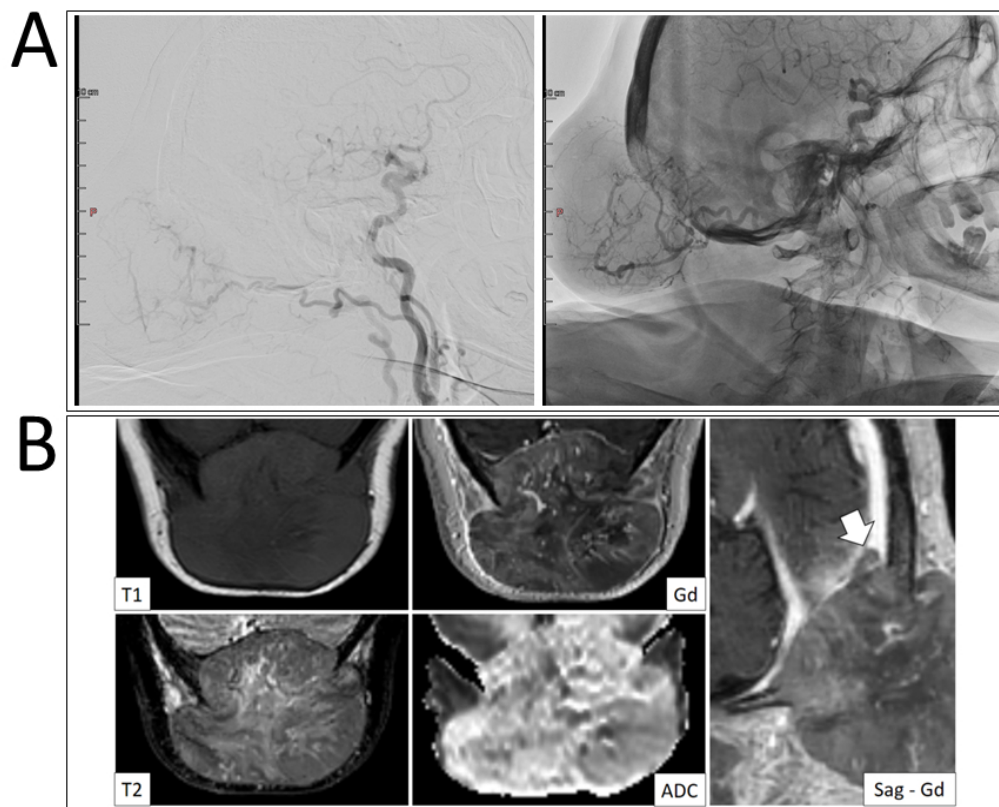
A) Angiographic image showing the rich arterial vascularization of the occipital neoplasm and the hypertrophy of the occipital arteries. Technical notes: using a right transfemoral catheterization with a 5-F introducer, a selective study of the internal carotids, external carotids, and vertebral arteries was performed. The study demonstrated significant contributions to the lesion from the occipital arteries on both sides. Siemens Artis Zee angiography system. B) MR imaging (axial T1 Spin Echo (T1-SE) before and after injection of gadolinium (Gd); axial T2 Fast Spin Echo (T2-FSE); Apparent Diffusion Coefficient (ADC)). Occipital mass, heterogeneously hypointense in T1 and hyperintense in T2, characterized by moderate heterogeneous contrast enhancement. No significant diffuse restriction was detected by diffusion-weighted imaging (ADC map). On the sagittal plane, post-gadolinium T1-weighted imaging (Sag T1-Gd) demonstrated findings consistent with thrombosis of the superior sagittal sinus (white arrow). Technical notes: MRI was performed using a Philips Achieva T-Stream 1.5T system.
